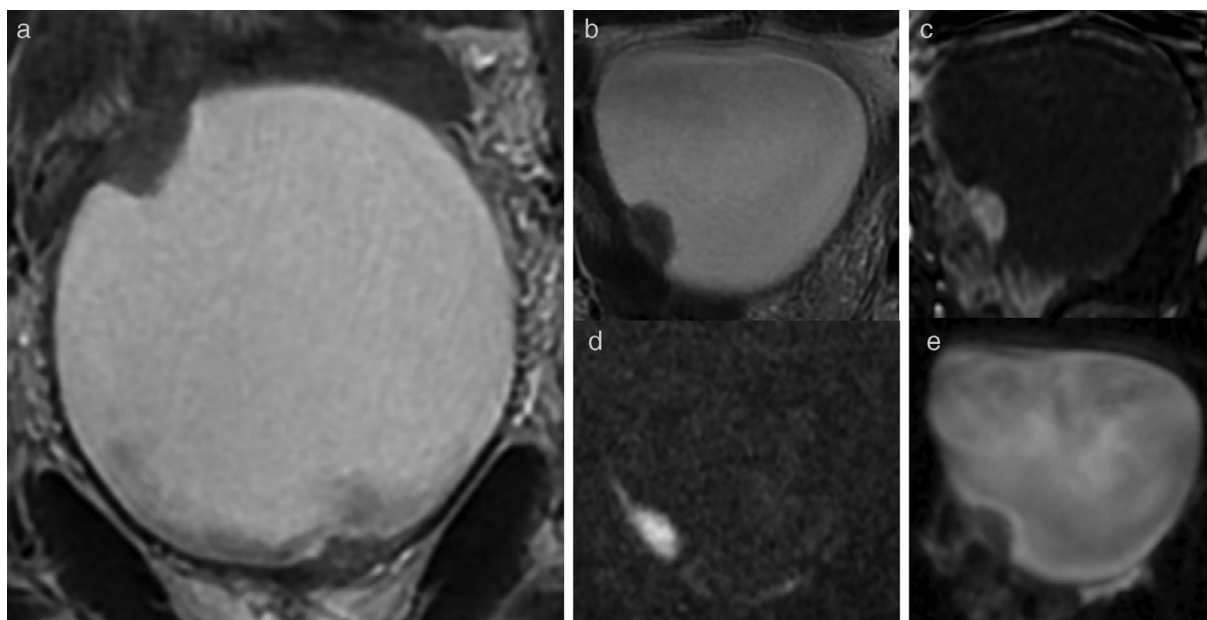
A 72-year-old male with positive cystoscopy. (a,b) T₂W imaging (coronal, axial plane) shows a sessile mass >1 cm in size at the level of the right lateral bladder wall/dome of the bladder, with intermediate SI that extends through the muscularis propria. T₂W imaging assigned as VIRADS category 4. (c) DCE imaging shows early and heterogeneous enhancement of the lesion, extending through the muscularis propria. DCE assigned as VI-RADS category 4. (d,e) DWI (b = 2000) and ADC maps show a lesion with significant restricted diffusion, extending through the muscularis propria. DWI assigned as VIRADS category 4. Overall VI-RADS score was 4.
